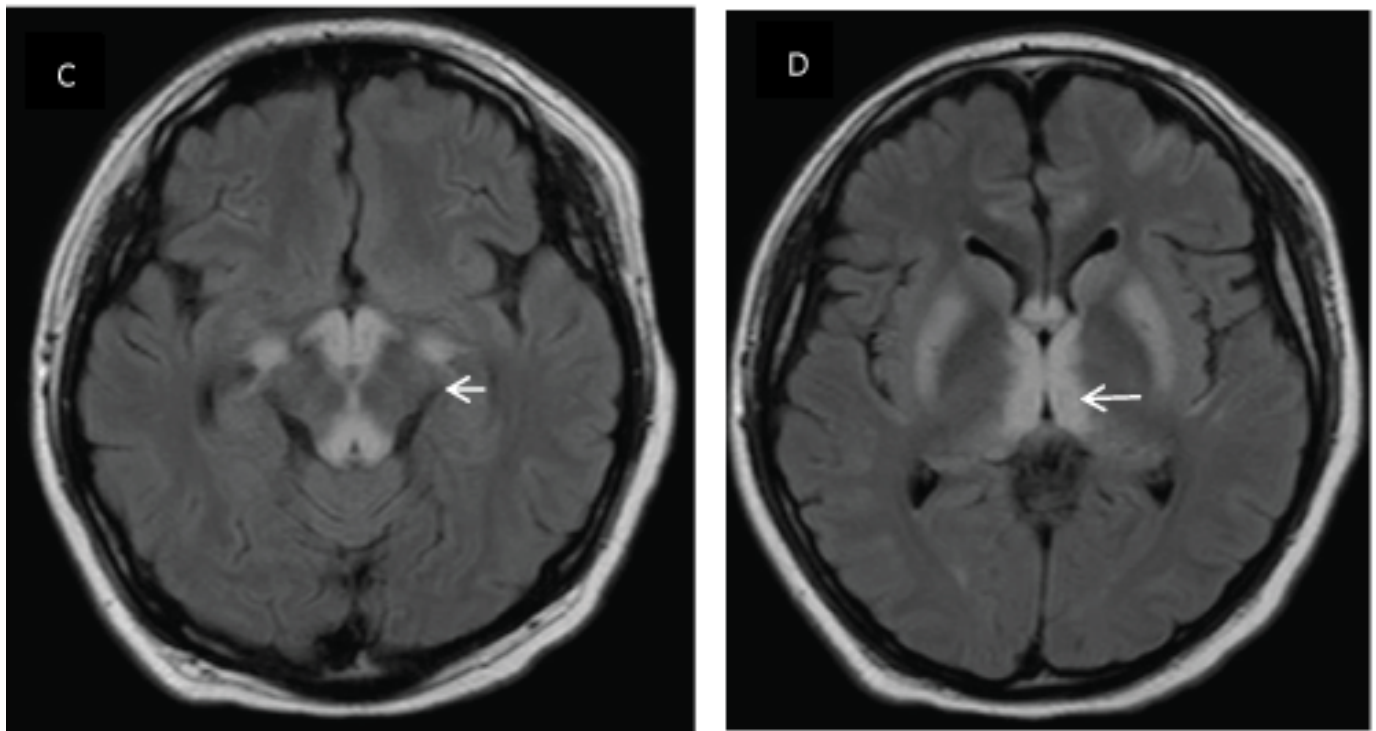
(A,B): MRI brain (FLAIR) at beginning, there are bilateral simetri hyper intense lesions incuad rigeminal tuberculosis, periacue ductal gray matter and fornix.
